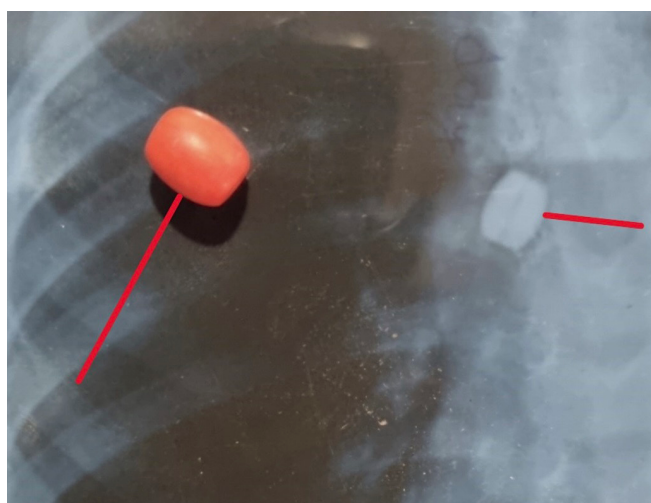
Photo of the foreign body (red bead) after expulsion from the lungs. The same bead is also identified by X-ray (white) prior to expulsion from the lung. (Photo Credit: Juma Santino)
